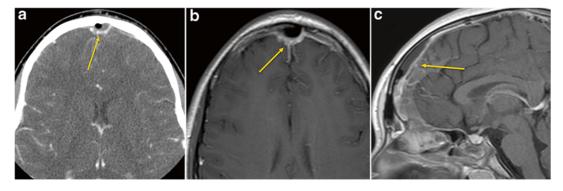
Epidural empyema. (a) Contrast axial CT image shows peripherally enhancing epidural empyema in the midfrontal area with focal air bubble within it. There is associated adjacent dural thickening and enhancement. (b) Postcontrast axial and (c) sagittal T1 MRI shows peripheral enhancing epidural empyema with adjacent fluid opacification and mucosal thickening in the frontal sinus
